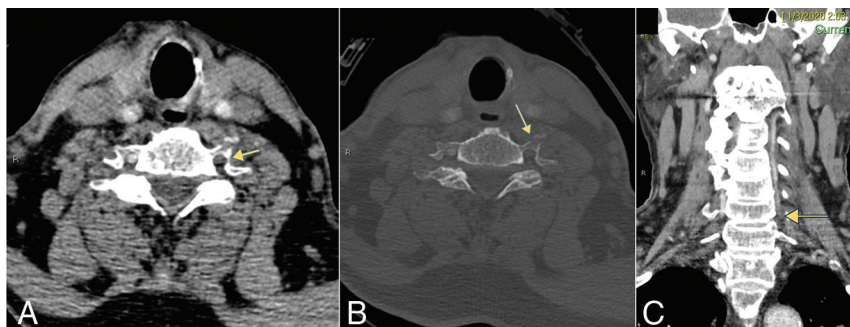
CTA of a 71-year-old male patient shows absent vascular opacification (arrow) in an occlusive dissection of the left vertebral artery (A). There is a mildly displaced fracture of the left transverse process/foramen of C5 (arrow) evident on the corresponding bone window (B). The coronal reconstructed image demonstrates occlusion of the V1 and proximal V2 segments and the absence of flow below the C6 vertebral level (grade IV) (arrow) (C), with a reconstituted left vertebral artery above from collaterals.
